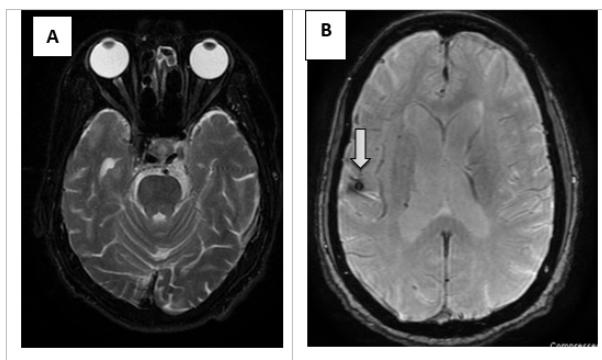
Follow up MRI and MRA after 3 months of post embolization found tranavenous embolization coils and glue without residual dAVF with resolution of venous congestion at anterior right temporal lobe and right frontal operculum without proptosis (A), leaving only a few tiny hemorrhagic spots and superficial siderosis (arrow head-B).
